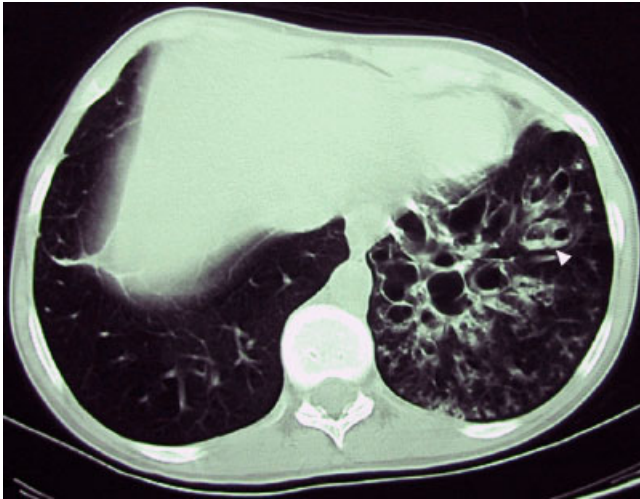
Computed tomography (CT) of the chest from Patient III-4 demonstrating extensive bronchiectasis and air/fluid levels (arrow).
